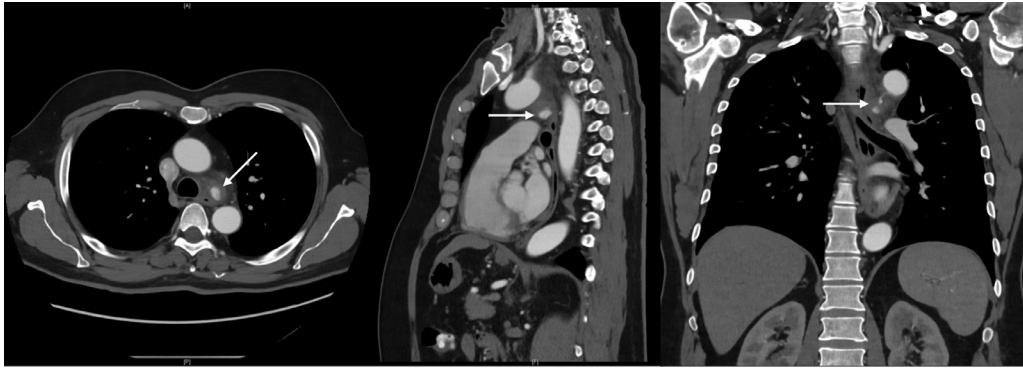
Contrast enhanced computed tomography of the chest (axial, sagittal, and coronal images) demonstrating the pseudoaneurysm originating from the distal arch with associated hematoma and fat stranding under the arch of the aorta; arrows locate the pseudoaneurysm.
